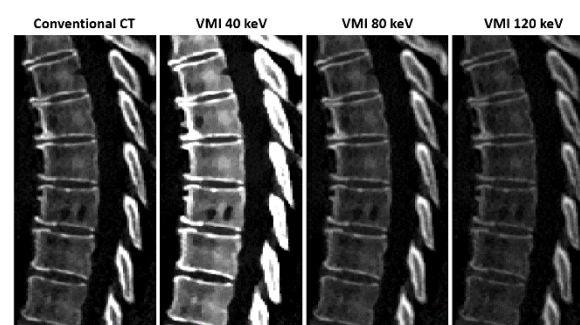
Example of available data with lytic lesions (multiple myeloma disease) in different parametric images (from left conventional CT, virtual monoenergetic images (VMI) at 40 keV, VMI at 80 keV, and VMI at 120 keV), all displayed using the same window width and center.
